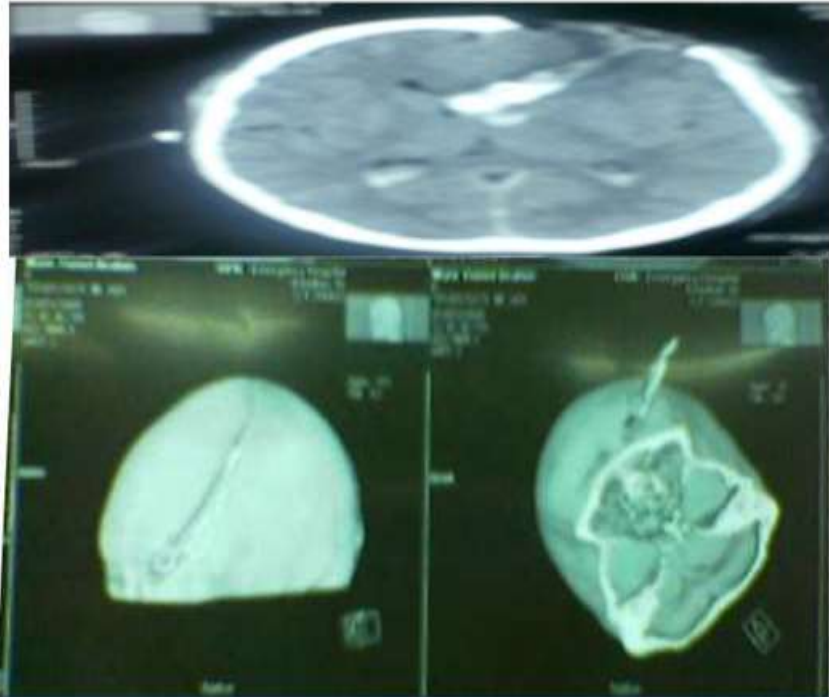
CT scan of brain Showed large left frontal cranial open comminuted depressed fracture extending to the left orbit.
